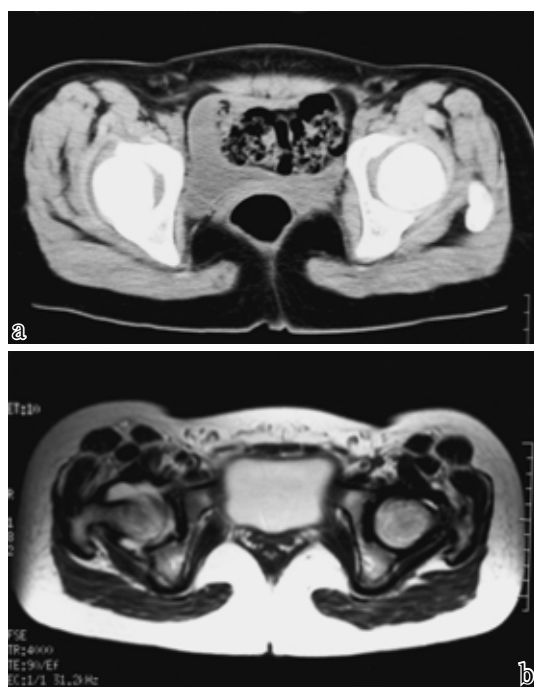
CT and MRI at 8 days after onset.
